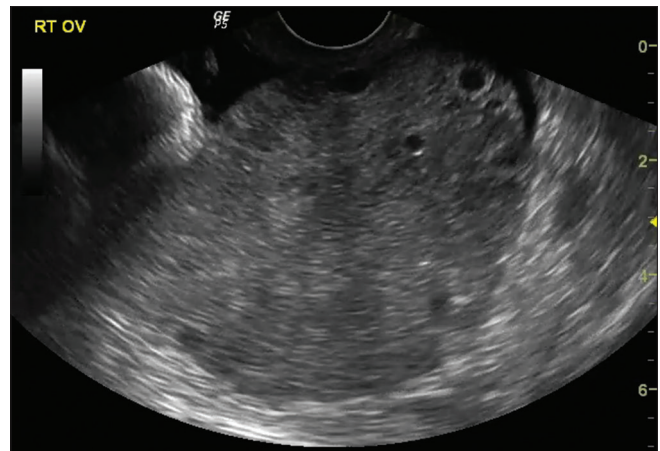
Ovarian torsion: An enlarged (141 mL), edematous ovary with prominent peripheral follicles is seen. No ovarian mass was seen, and color Doppler flow was present (not shown). Surgery confirmed ovarian torsion
